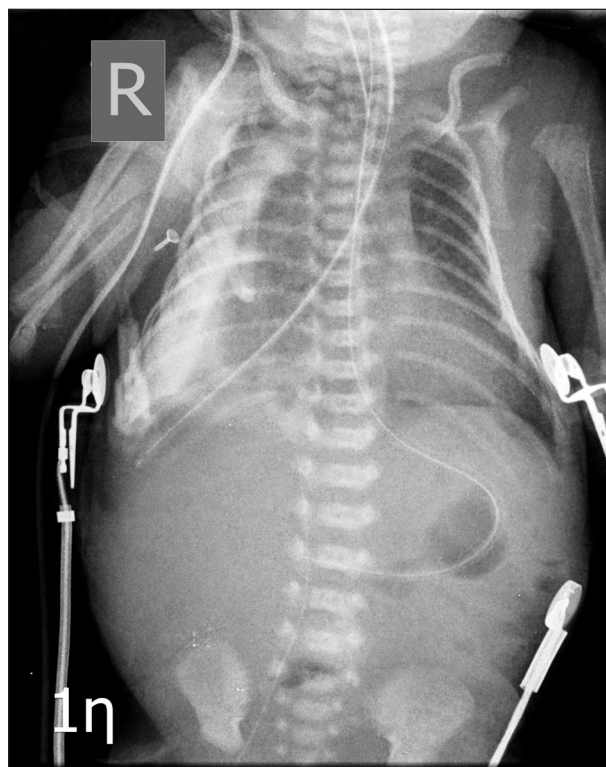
Chest radiograph showing the orogastric tube in its place, while a nasogastric one was inserted additionally and positioned appropriately.
